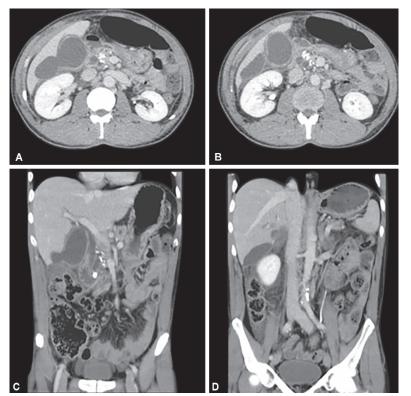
CT scan images; coronal view showing gallbladder perforation
